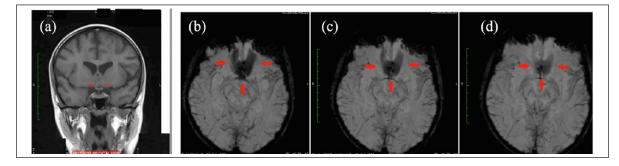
(a) MRI TI coronal images showing subacute heamorrhage (red arrows) in the anterior communicating artery area. (b–d) SWI showing loss of signal in the anterior communicating artery area (red arrows) suggestive of haemorrhage.
